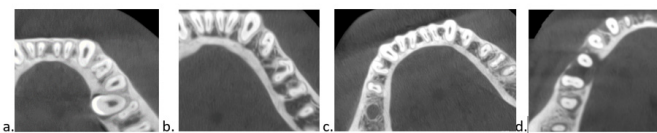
Examples of axial CBCT showing C-shaped canal types in mandibular premolars [a. C1 type (left mandibular first premolar), b. C2 type (left mandibular second premolar and C3 type (left mandibular first premolar), c. C3 type (right mandibular first premolar) and d. C4 type (right mandibular first premolar)]
